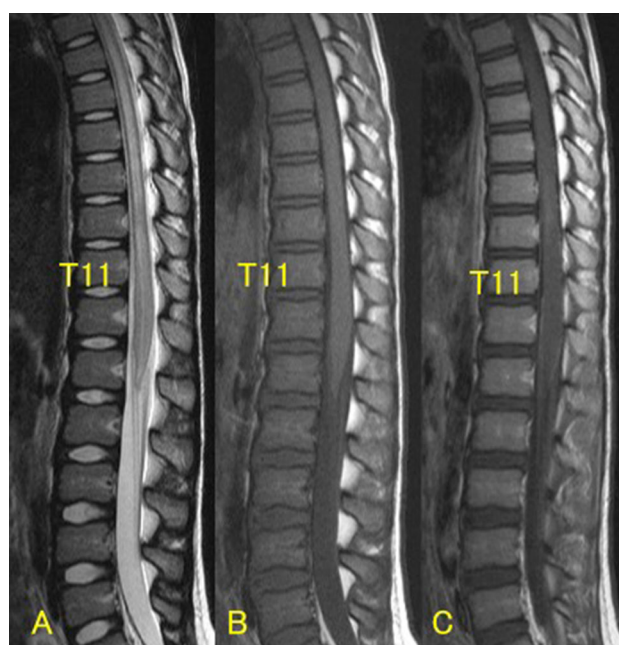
Magnetic resonance images (MRI) of the lumbar spine 1 day after trauma. T2-weighted MRI (a) shows increased signal change at T11 vertebral level with longitudinal signal change to cranial level. T1-weighted (b) and gadolinium-enhanced MRI (c) showed no signal change in the spinal cord, vertebral bodies, or intervertebral discs
